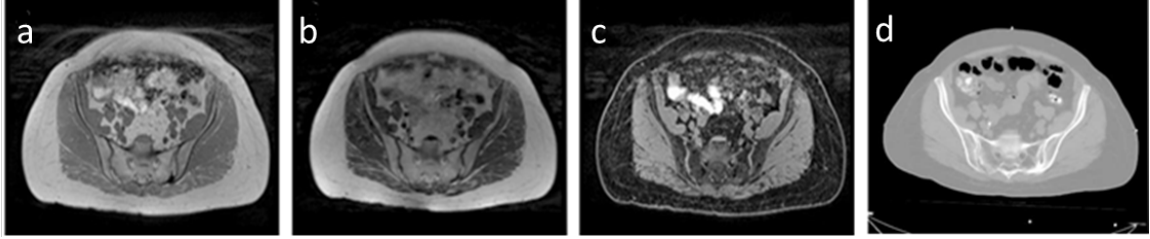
Example MR and CT images from one study subject. (a) T1-weighted (in-phase), (b) Fat, (c) Water and (d) CT image.
